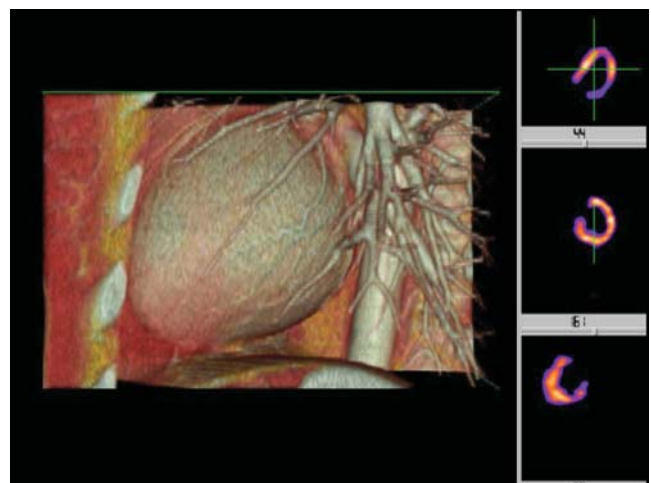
A Web-based image processing system provided this analysis and display of CT angiography, showing vessels in the lung and coronary vessels on the surface of the left ventricle.
